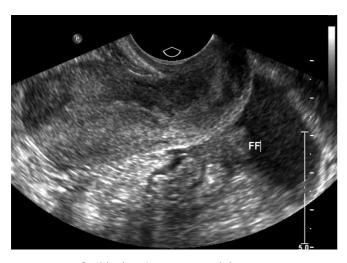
Free fluid (FF) in the posterior cul-de-sac or rectouterine space, as seen on transvaginal ultrasound. Image courtesy of Monica Deshmukh, MD, Department of Radiology, Olive View-UCLA Medical Center, Los Angeles, CA.
